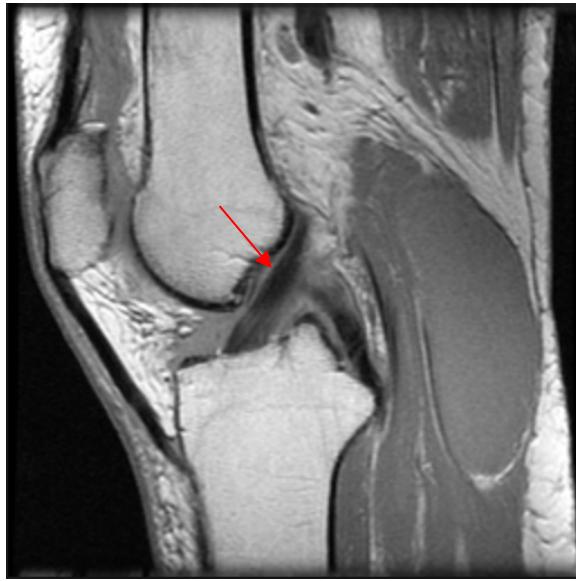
Sagittal view MRI of the knee showing intact ACL
